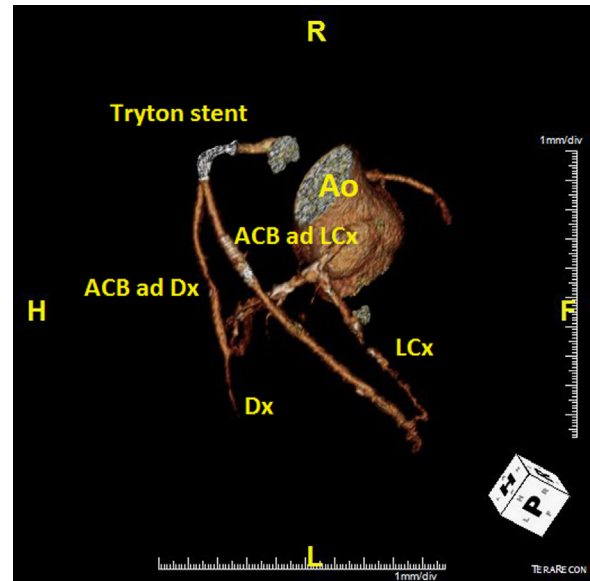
12 Month follow-up; MS-CT volume-rendered 3-D image.
